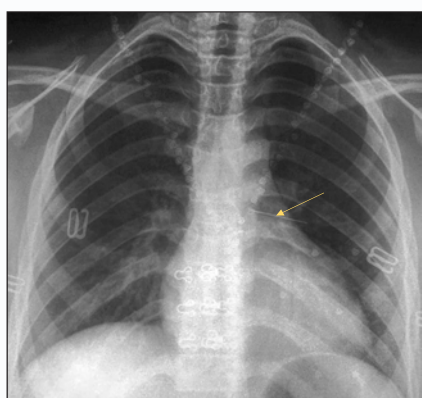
Chest X-ray performed on admission showing a linear opacity projecting over the left hilar region corresponding to the scarf pin location (yellow arrow).
